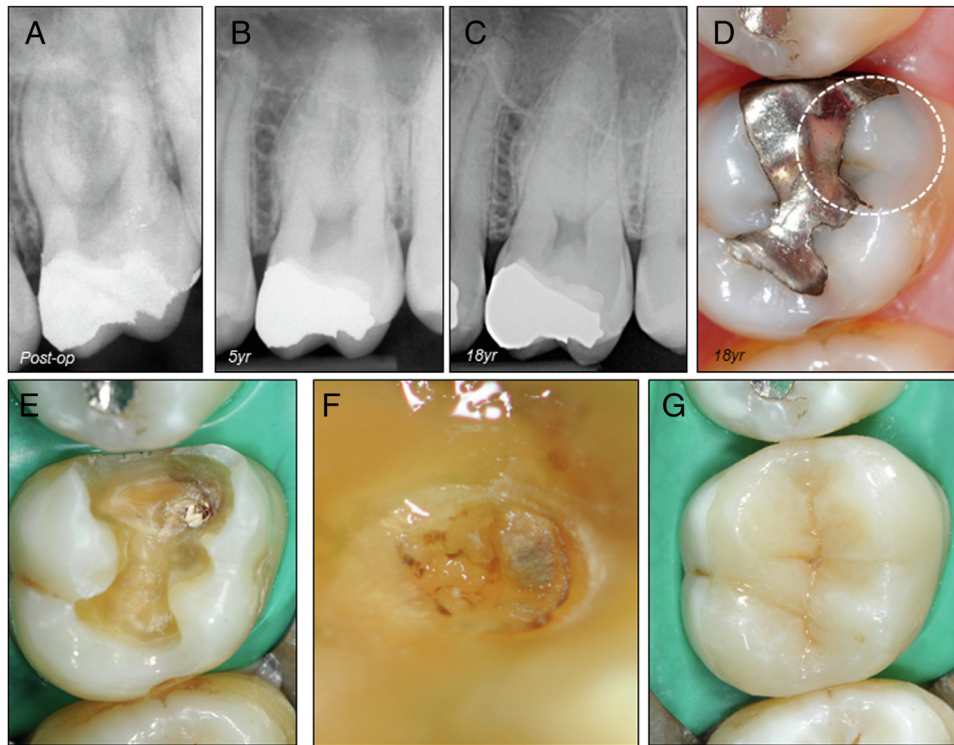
Maxillary first molar with deep caries in a 9 year-old boy. Provoked symptoms were present. Medium exposure of the mesiobuccal pulp horn. Bleeding was controlled in <3 minutes. The exposed pulp was capped with Dycal, followed by a layer of oxyphosphate cement. Cavity restored with amalgam. (A) Postoperative radiograph. (B) Five-year follow-up radiograph. The pulp responded to tests within normal limits. (C) Radiograph taken after 18 years. The tooth was comfortable, with normal response to tests. (D) At inspection, discoloration of the mesiobuccal cusp was noted (encircled), and probing revealed recurrent caries. (E) Removal of restorative materials and carious tissue. Remnants of Dycal over the calcified barrier formed at the area of the previous pulp exposure. (F) Close-up view of the calcified bridge after removal of Dycal. (G) The crown was restored with an onlay.
